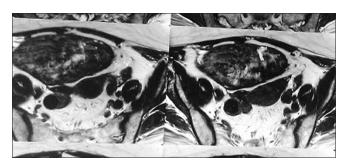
MRI PELVIS (original)
